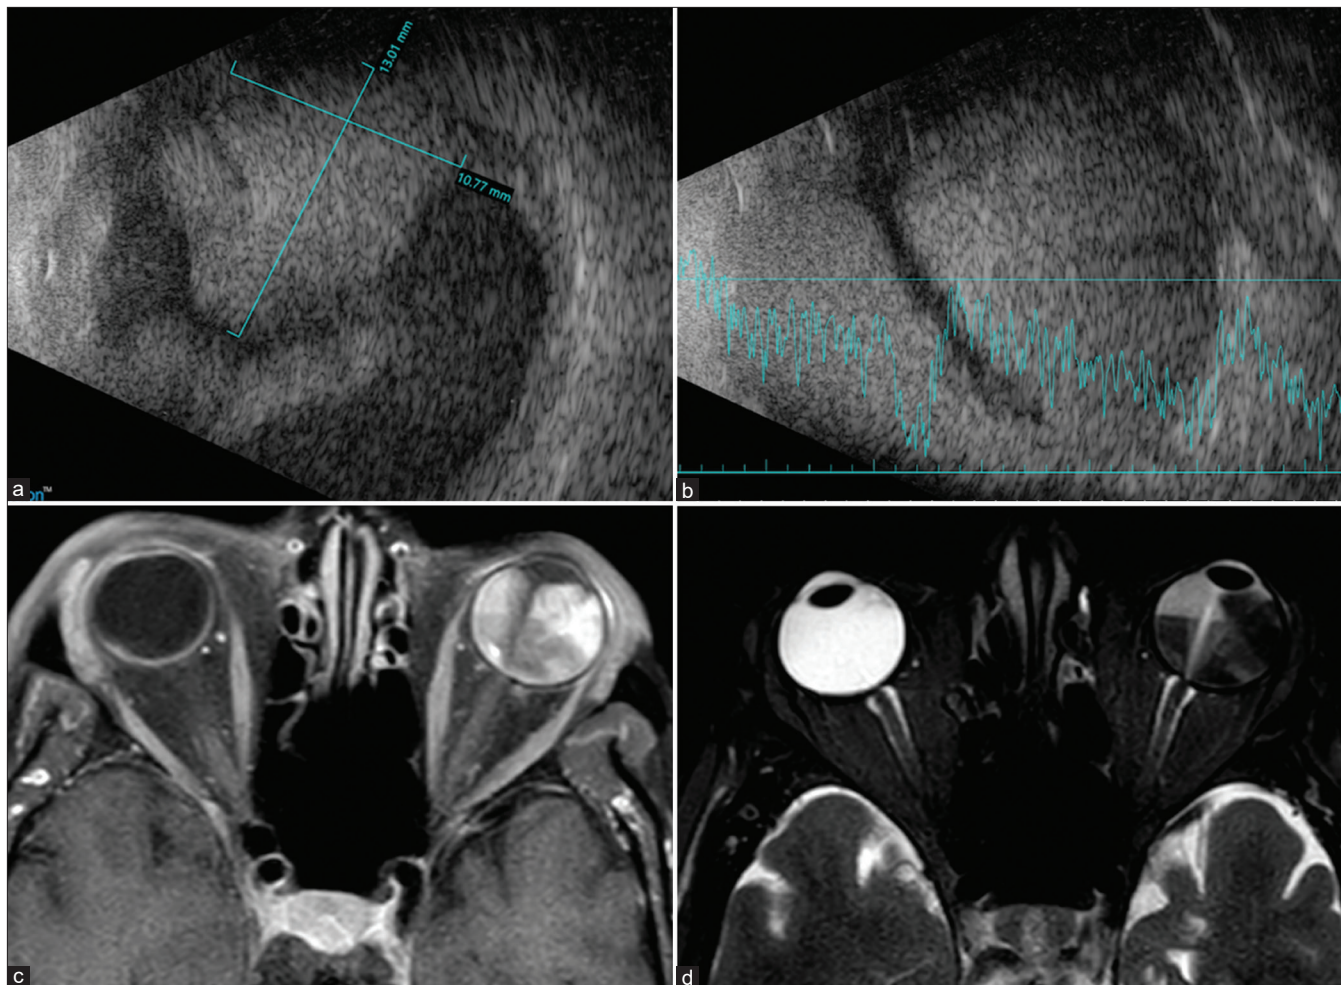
Ocular imaging. (a and b) Ultrasound A and B scans. Total bullous retinal detachment with extensive low to moderate reflectivity, subretinal echoes suggestive of intraocular hemorrhage, and an ill-defined mass lesion having moderate internal reflectivity in temporal aspect of the globe. (c and d) MRI orbit with contrast. Extensive retinal detachment with enhancing heterogeneous subretinal mass in superolateral aspect of left eye, which is moderately hyperintense on T1-weighted images (c) and moderately hypointense on T2-weighted images (d). MRI = magnetic resonance imaging
